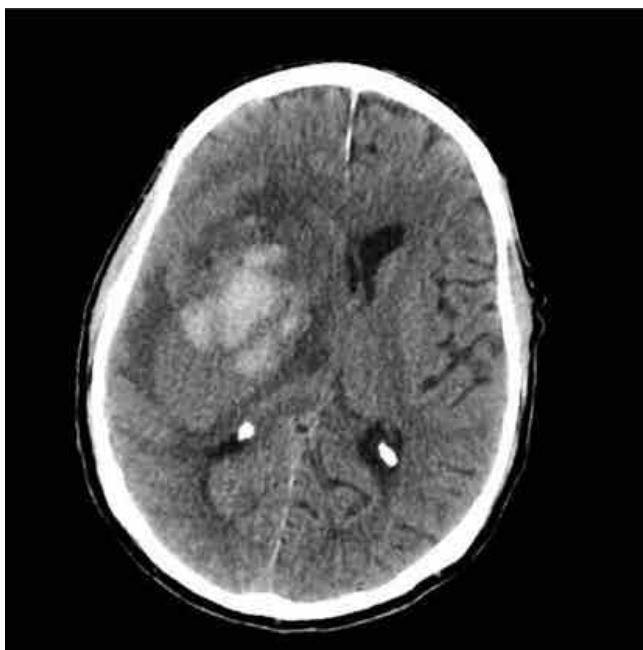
Patient B: cerebral CT shows a large right intraparenchymal hemorrhage with surrounding edema involving the fronto-temporo-parietal areas. Recall that in the CT scans, the right hemisphere is shown on the left.
